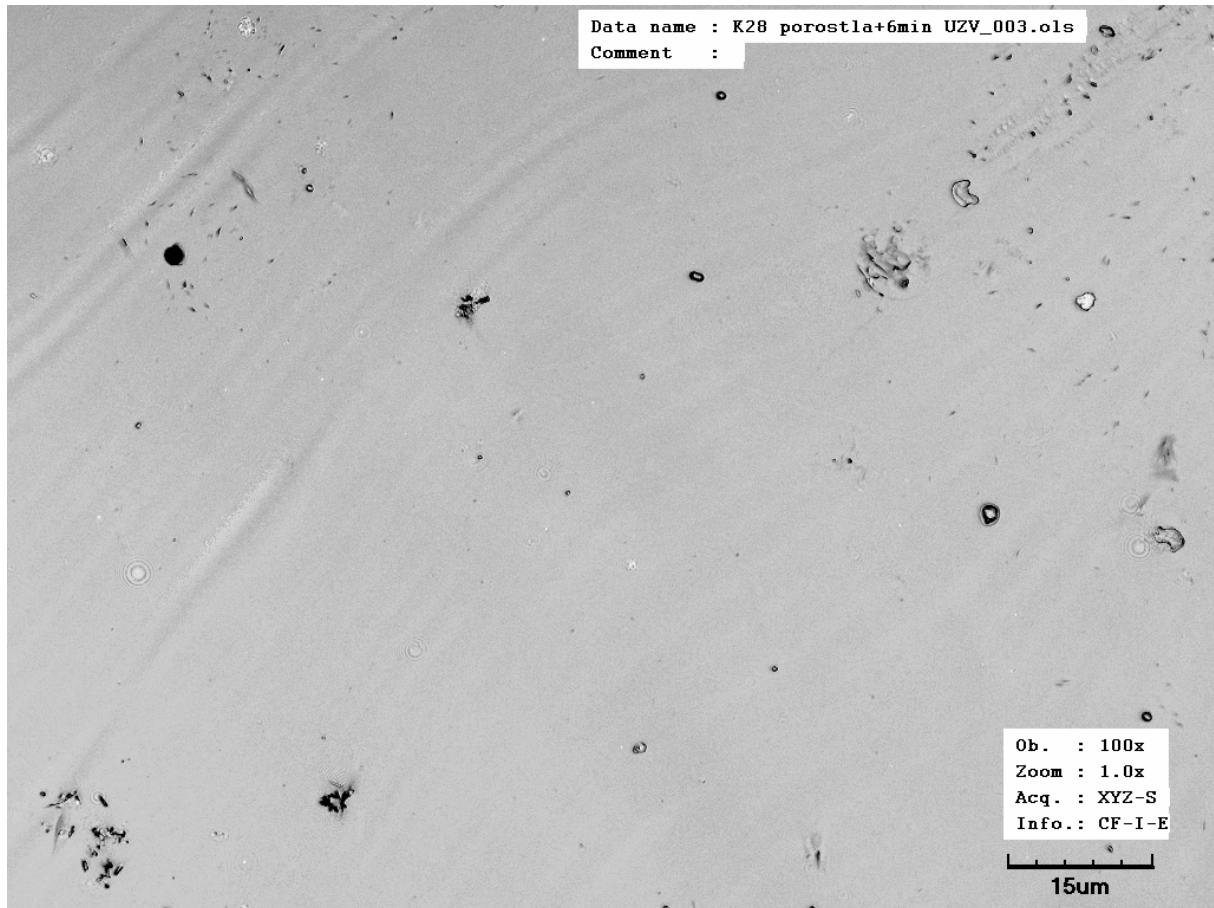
S.mutans* has been completely removed after 5 minutes in an ultrasound bath.
